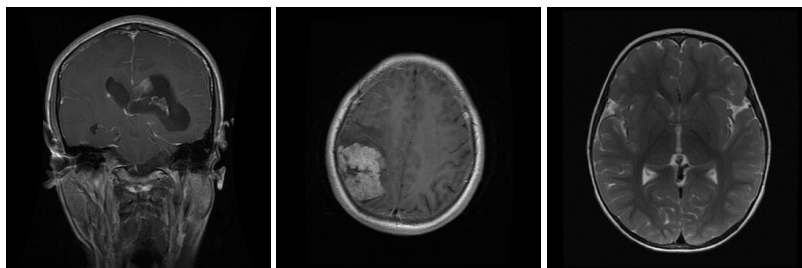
Sample images of brain tumor MRI dataset, Each image corresponds to a prediction class in the data set glioma (Left), meningioma (Center) and No tumor (Right)
